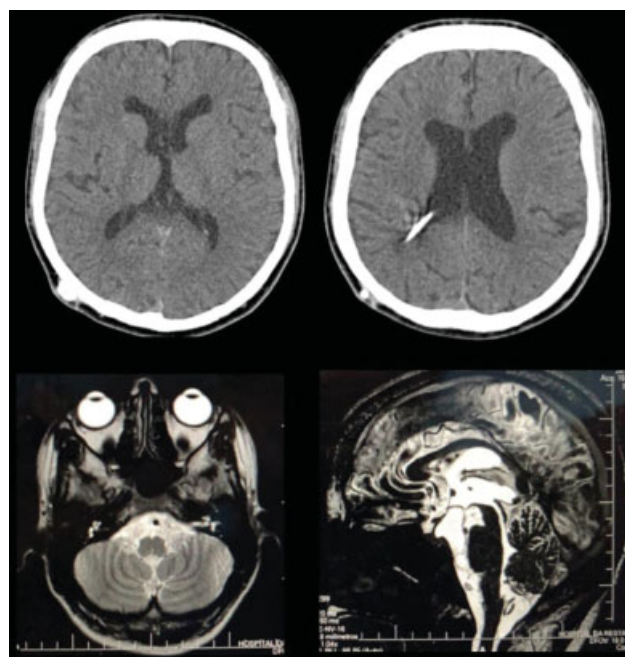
Brain computed tomography scan without contrast showing no lesions or signs of hydrocephalus (upper). Brain magnetic resonance imaging showing no fossa posterior.
